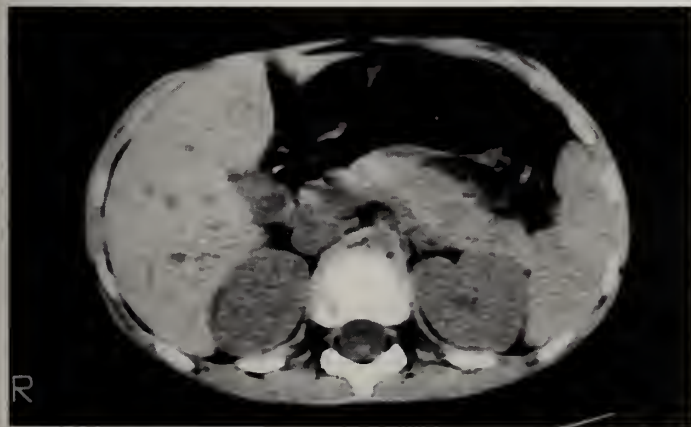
These computed tomograms show (A) resolution of the pseudocyst immediately following percutaneous aspiration and (B) complete resolution 2 months following injury.
